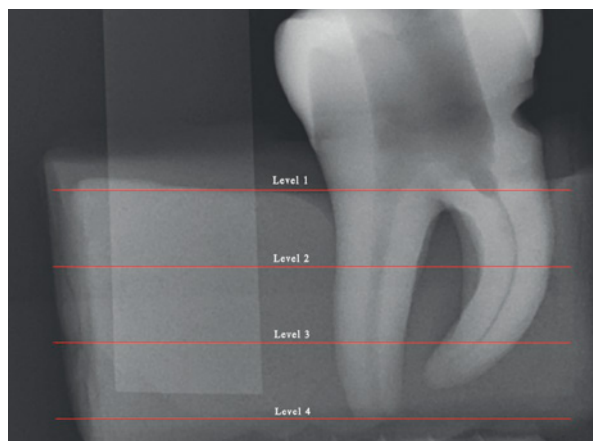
X-ray from bucco-lingual projection showing the distal root canal divided into four equal levels
